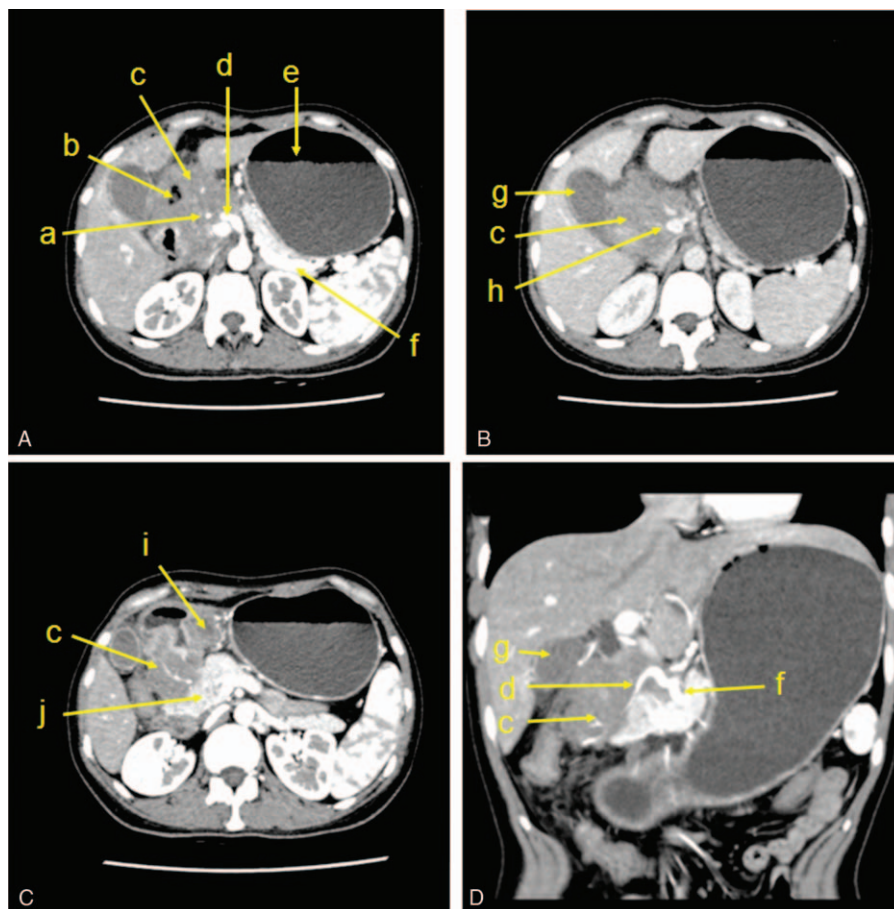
Abdominal CT, (A) (arterial phase): the tumor invades the hepatic portal and gallbladder, and surrounds the proper hepatic artery, right hepatic artery, and left hepatic artery. (B) (Venous phase): the tumor surrounds the portal vein. (C) (Arterial phase): the lower end of the tumor invades the caput pancreatis. (D) (Coronal view in arterial phase): the tumor invades the proper hepatic artery. a: right hepatic artery, b: enteric cavity of duodenum, c: tumor, d: proper hepatic artery, e: stomach, f: splenic artery, g: gallbladder, h: portal vein, i: duodenal bulb, and j: pancreas.
